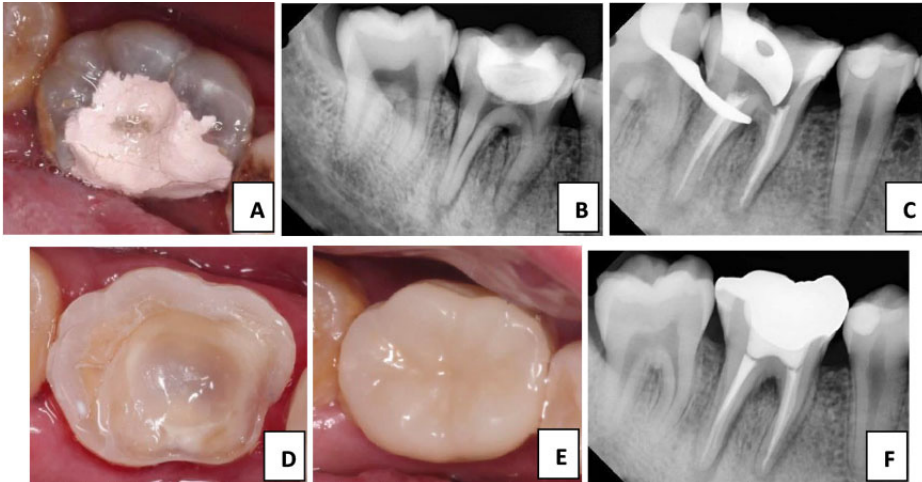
(A) Clinical condition of tooth #46, (B) Pre-operative radiograph, (C) Obturation of the root canals, (D) Endocrown preparation, (E) Cementation of endocrown, (F) Radiographic examination after crown cementation.
